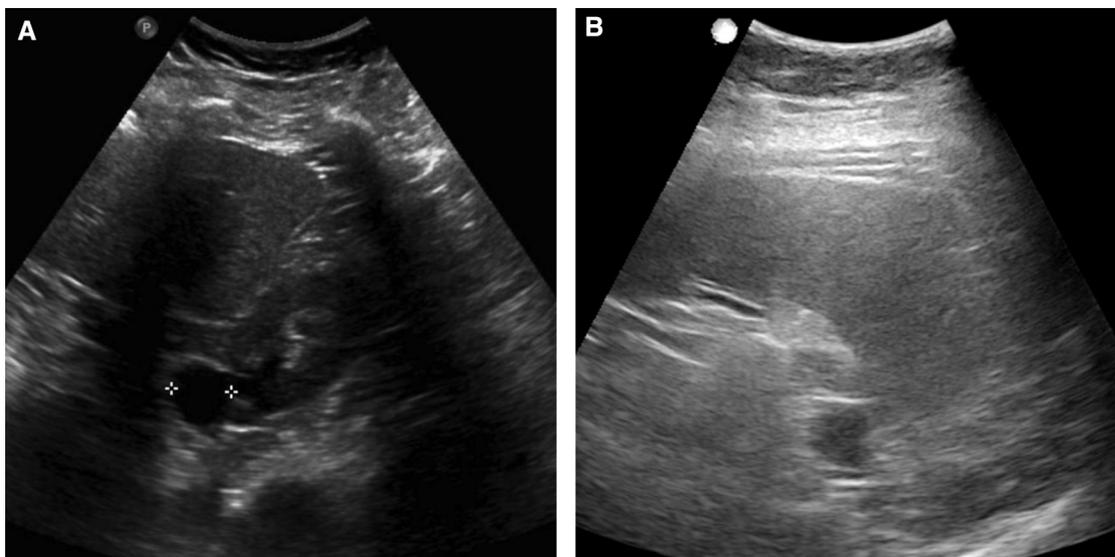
Transverse view of a 1.8-cm left renal cyst in a 45-year-old woman using the (A) EPIQ 5 (conventional) ultrasound system and (B) SonixTablet/MELODY (telerobotic) system. Overall, images from the telerobotic system were more hyperechoic than images from the conventional system.
